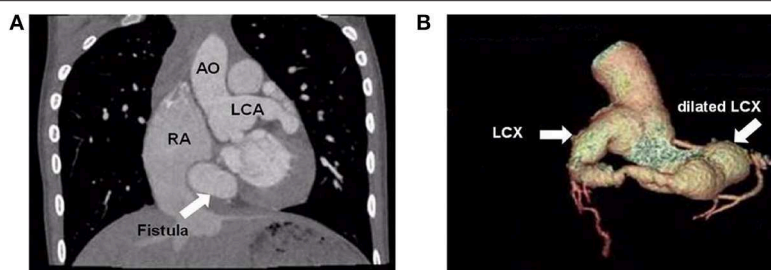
Cardiac computed tomographic view the dilated left main coronary artery and circumflex artery. (A) Cardiac computed controlled X-ray shows dilated left main coronary artery and right atrium. The arrow points to the fistula. (B) Three-dimensional reconstructed computed tomographic demonstrates the dilated left circumflex artery. The distal left circumflex artery showed an aneurysmal dilatation. AO, aorta; LCA, left coronary artery; RA, right atrium; LCX, left circumflex artery.
